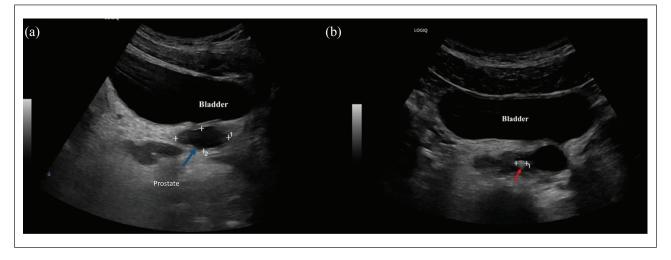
(a) A pelvic ultrasound image showing a cystic structure measuring approximately $3 \text{ cm} \times 1.4 \text{ cm}$ located to the left of the prostate gland (blue arrow), which represents cystic dilatation of the left seminal vesicle. Note the urinary bladder is anterior and the prostate is posterior to the structure. (b) The above image shows a calcified focus measuring approximately 0.5 cm located at the terminal segment of the left seminal vesicle (red arrow), resulting in obstruction of the left ejaculatory duct.
